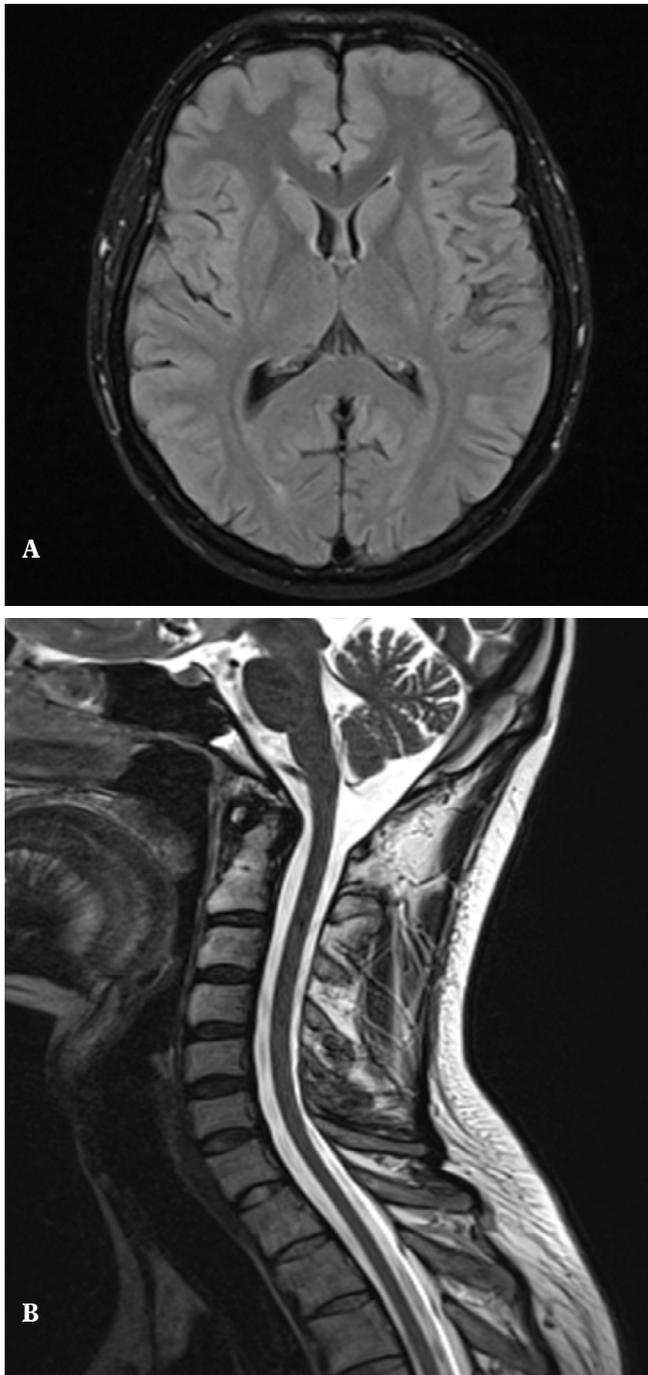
A complete MRI scan of the brain (A) and spinal cord (B) did not reveal focal lesions and features of atrophy.
